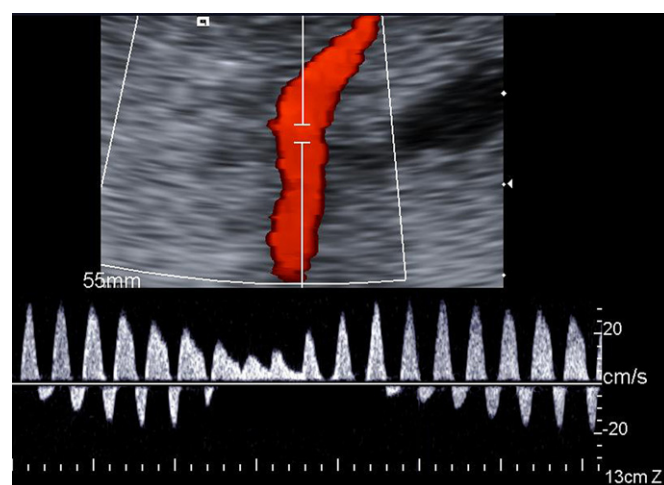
Pulsed Doppler insonation of a large placental arterio-arterial anastomosis, showing the characteristic bidirectional periodic pattern resulting from the collision of two opposite systolic waveforms.
